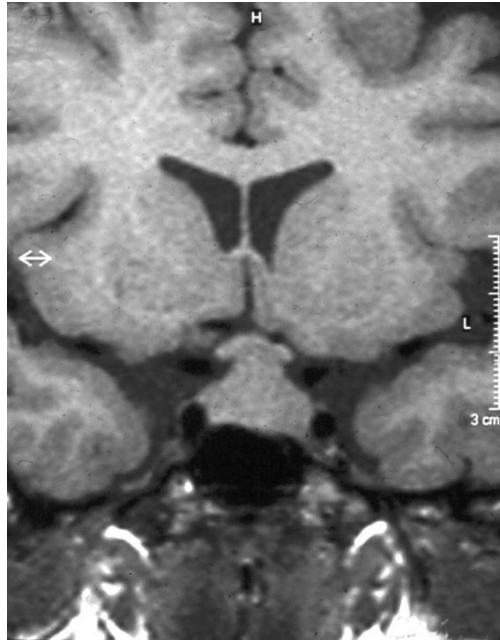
Craniopharyngioma: T1 weighted coronal MRI showing a cystic suprasellar lesion arising above and behind the chiasm. (Kidd et al., 2006)
